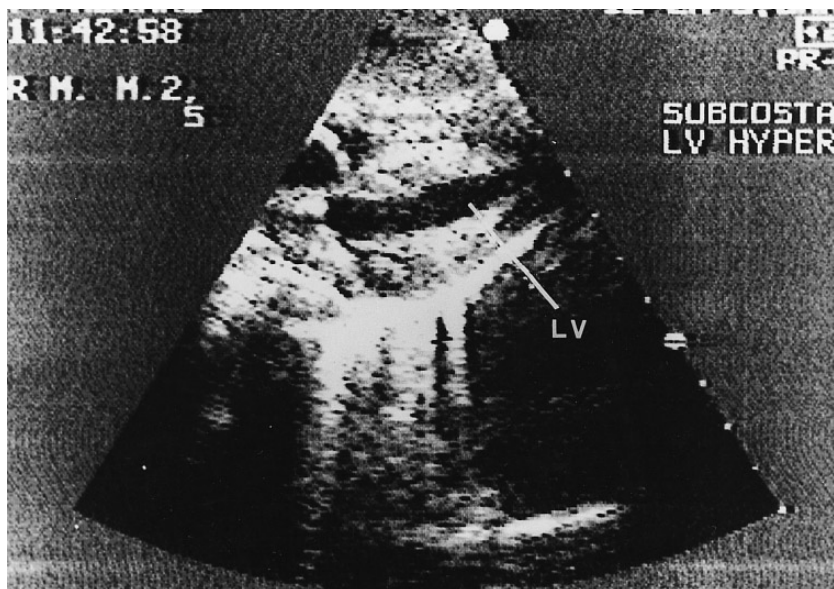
Echocardiogram at 2 months of age showing marked hypertrophy of the left ventricle (LV).
